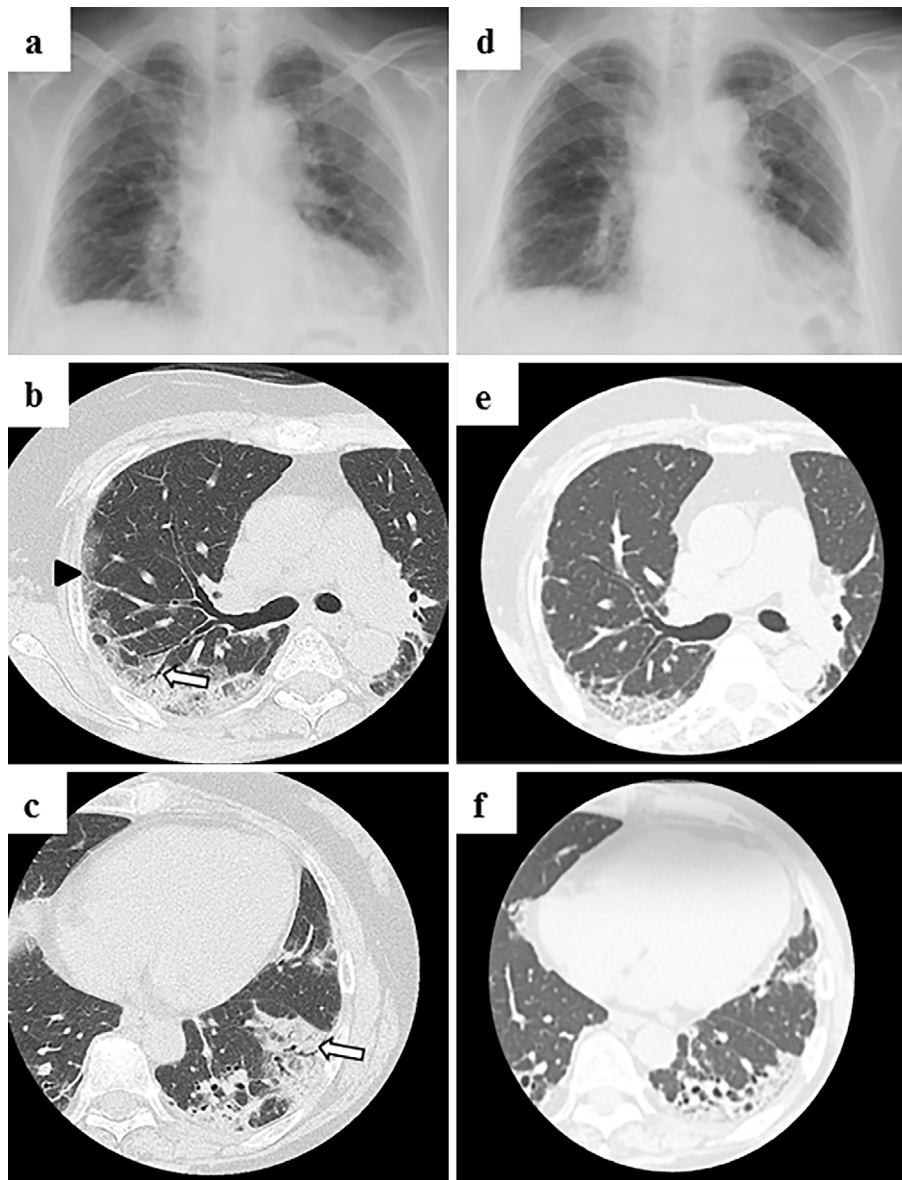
Pulmonary manifestations at the initial diagnosis (a, b, and c) and on the 106th day of hospitalization (d, e, and f). Chest radiograph (a) shows consolidations and GGOs in the bilateral lung fields and decrease in the basal lung volume at the initial diagnosis of interstitial lung disease. HRCT (b, right middle lung zone and c, left lower lung zone) shows patchy consolidations and GGOs (arrowhead) with dilated air bronchogram (white arrows). Lung volume loss in the bilateral lung fields at the 106th day of hospitalization is indicated on chest radiography (d). Bilateral consolidations and GGOs are shown to be reduced on chest HRCT (e and f). GGOs: ground-glass opacities, HRCT: high-resolution computed tomography
